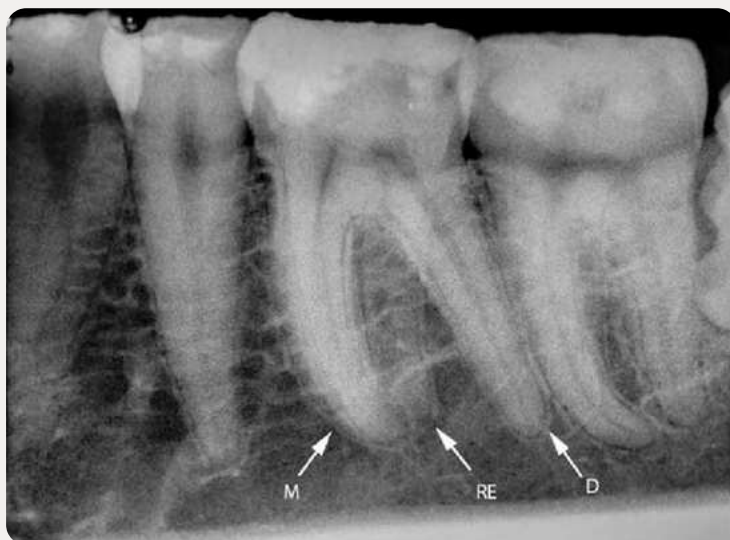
Three-rooted left mandibular first molar on the periapical radiograph of a 26-year-old male patient. M -mesial root, D -distal root, RE -radix entomolaris. From Strmšek, L., & Štamfelj, I. (2019). The prevalence of three-rooted permanent mandibular molars in a Slovenian population: A radiographic study. *Anthropologischer Anzeiger; Bericht über die biologisch-anthropologische Literatur*, 76(2), 121-127. <https://doi.org/10.1127/anthranz/2019/0942>
